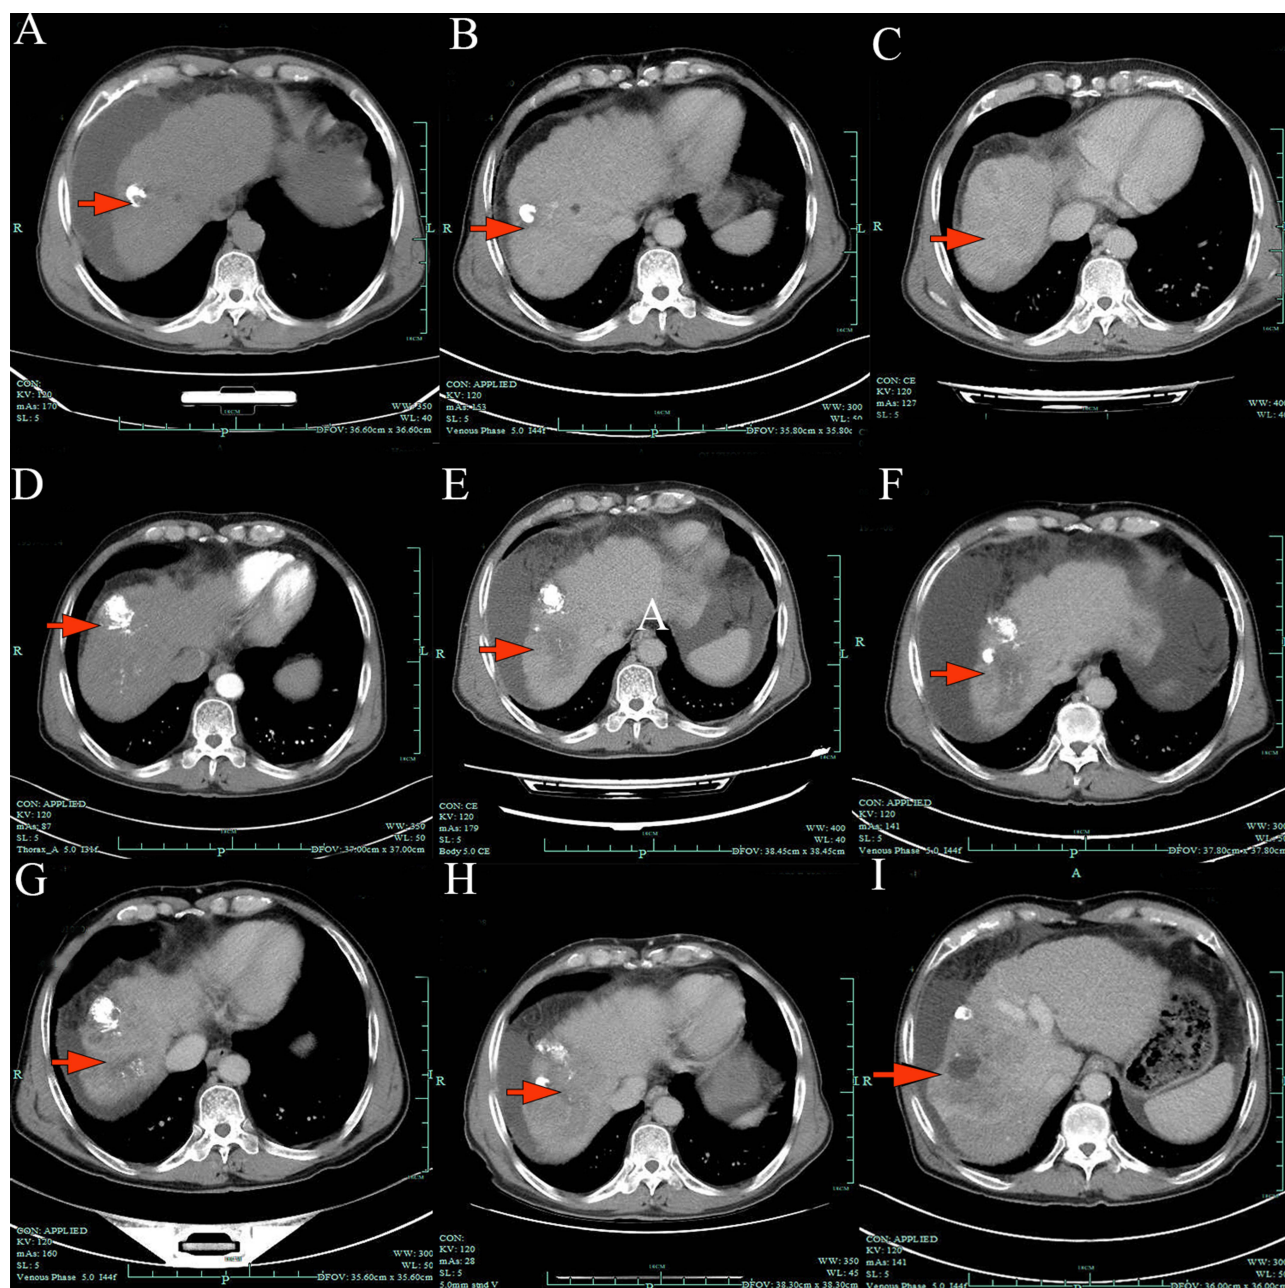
CT variations of intrahepatic lesions during treatment (red arrowheads). (A) June 2023. (B) July 2023. (C) September 2023. (D and E) November 2023 and January 2024. (F and G), March and May 2024. (H), June 2024. (I), July 2024.
